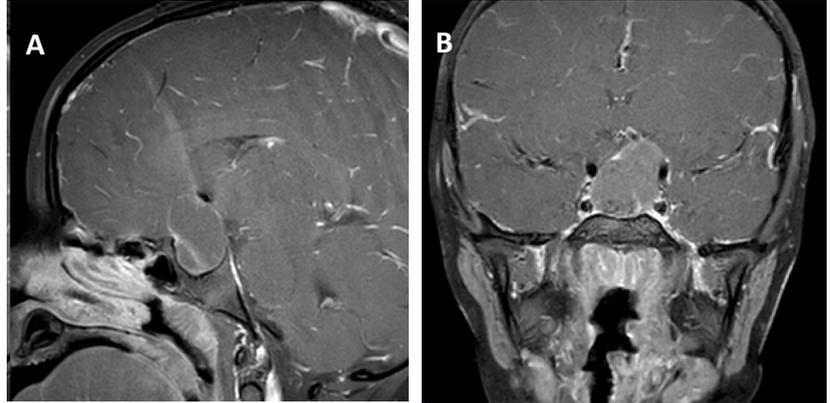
Contrast-enhanced T1 Sagittal (A) and Coronal (B) MRI demonstrating sellar and suprasellar cystic lesion consistent with recurrent craniopharyngioma
